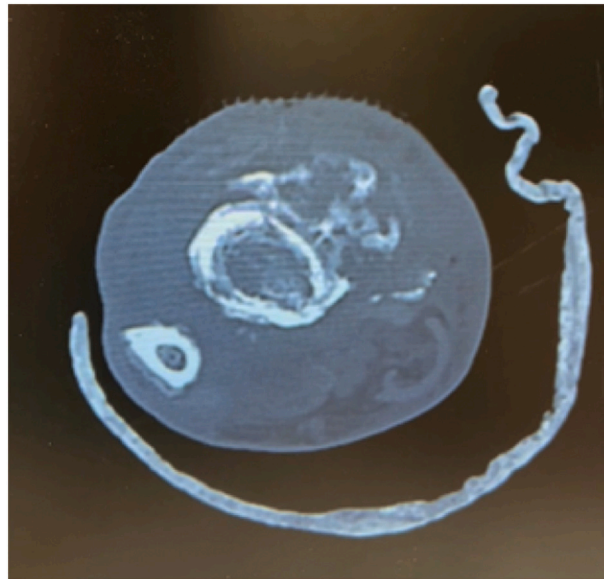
CT showing complete transverse fracture of right distal tibia and fibula with an irregular rim-enhancing collection that tracks to a dermal indentation.
